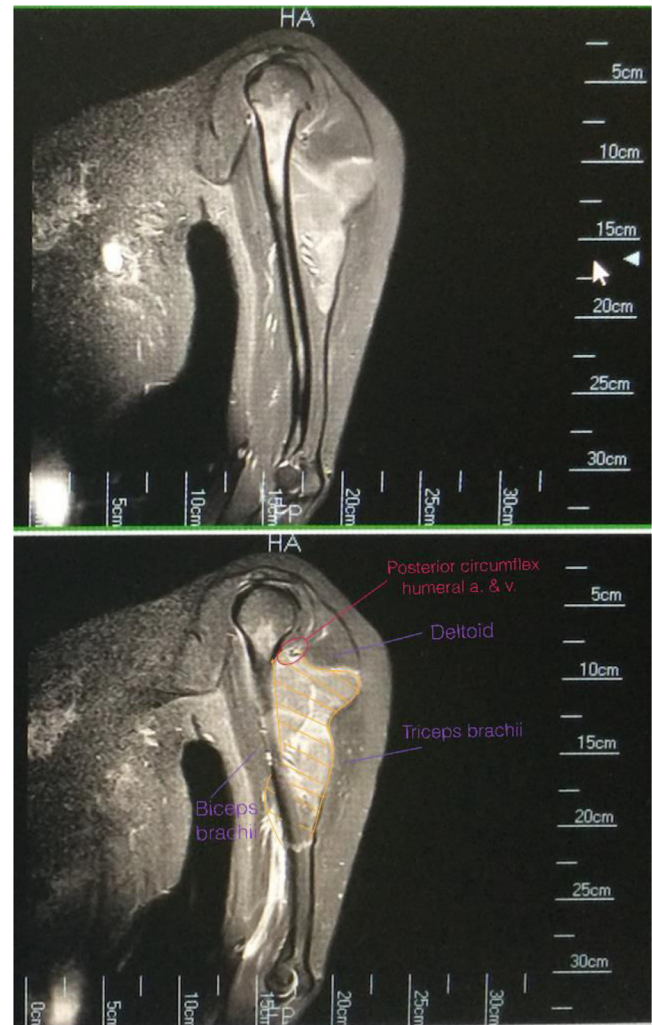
Soft tissue mass visualized on sagittal STIR MRI images. Overall dimensions of lipomatous tissue (highlighted in gold) measured approximately 12 cm craniocaudal by 8 cm transverse by 4 cm AP.
